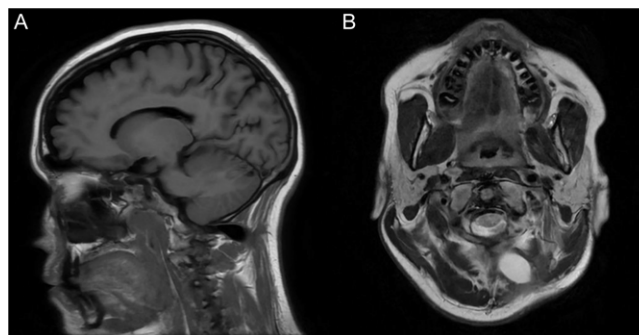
Follow-up magnetic resonance imaging of cervicomedullary junction. A–B: Scans on PID#61 revealing reduction in pseudomeningocele in sagittal T1-weighted (A) and coronal T2-weighted (B) MRI views. Demonstrating symptom resolution and pseudomeningocele improvement, she was discharged to inpatient rehabilitation 43 days post-injury. On PID#61, the patient underwent an MRI for ongoing, nonpositional headaches. The pseudomeningocele was identified and further reduction in size to 2.9 × 1.4 cm was confirmed (Figure 2, panels A–B).
